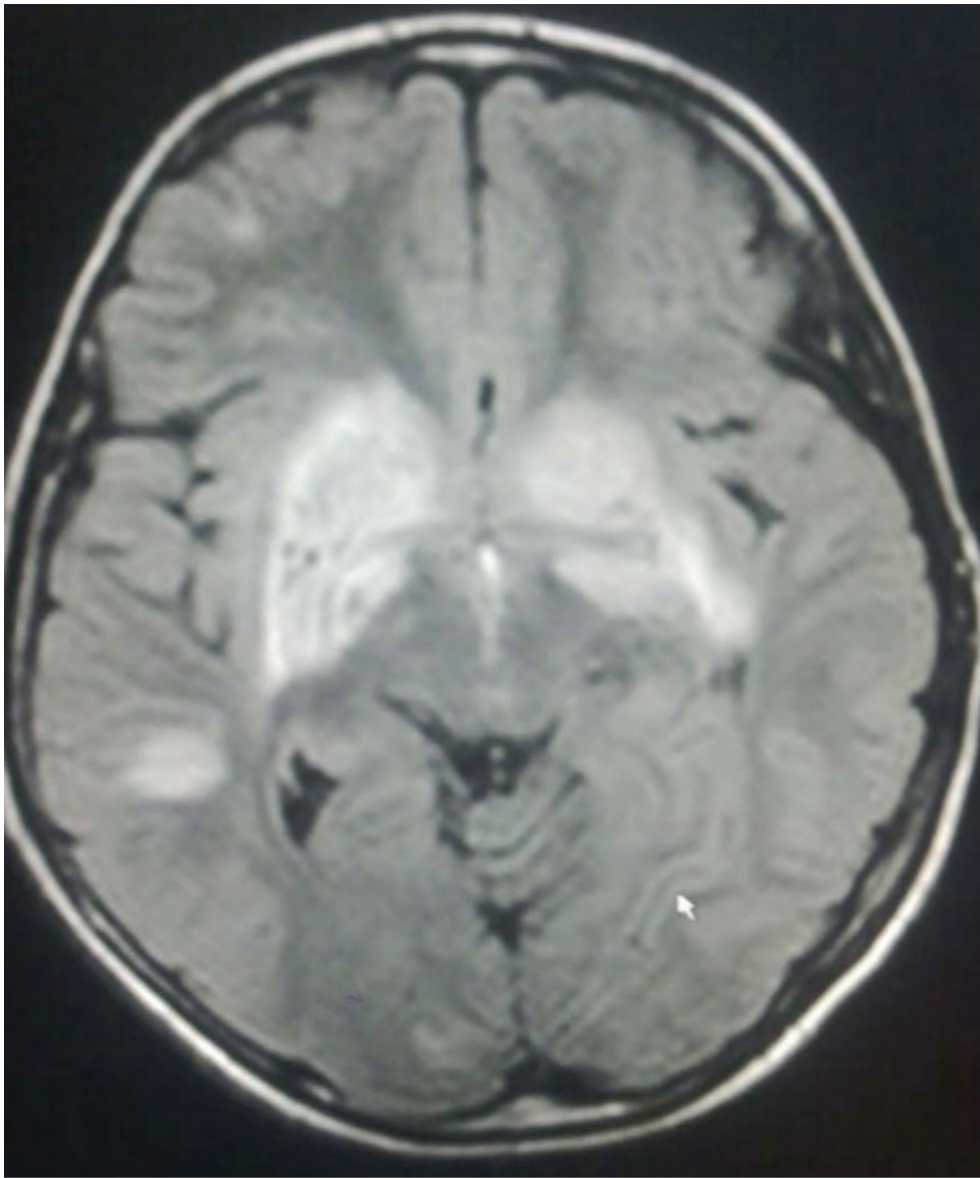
MRI T2 image: Bilateral hyper-intense signals involving the basal ganglia and the thalamus. Additionally, multiple cortical-sub-cortical hyper-intense lesions are present in the frontal and parietal lobes bilaterally. Note the focal hyper-intense
